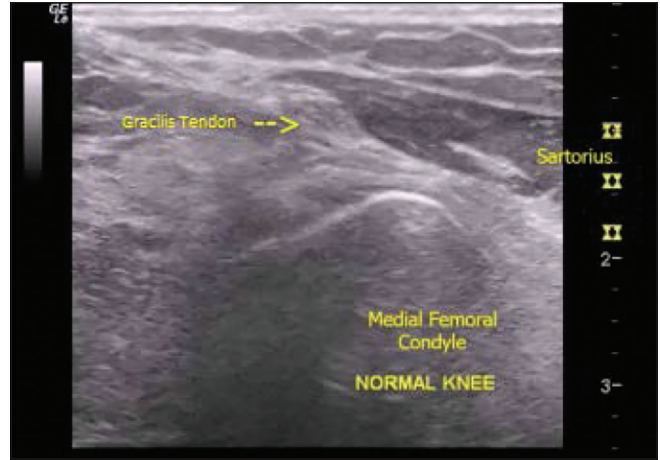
Normal left knee ultrasound – Case 1. A 31-year-old male with right knee pain. Contralateral normal left knee ultrasound showing the fixed gracilis tendon posterior and deep to the sartorius muscle belly. The top of the picture is medial, the bottom is lateral, left side is posterior knee, and right is anterior knee. Dynamic flexion and extension ultrasound of the normal knee is shown in Supplemental Video 2.
